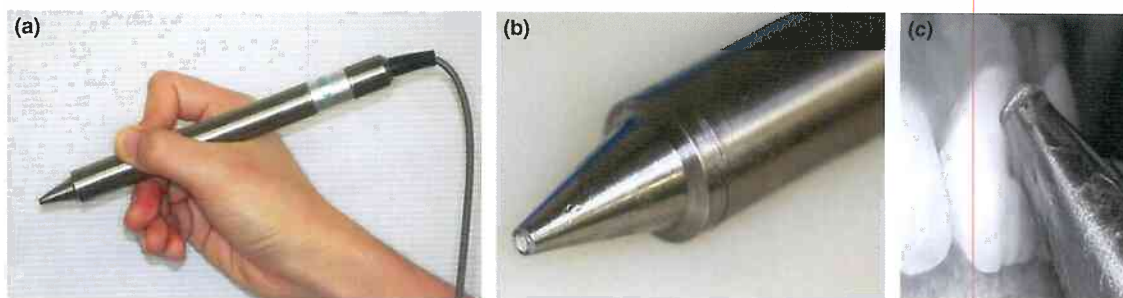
Ultrasonic probe of the Minimax Doppler machine. (a) Picture of ultrasonic probe held in a hand. (b) Tip of the ultrasonic probe. (c) Measurement position.
